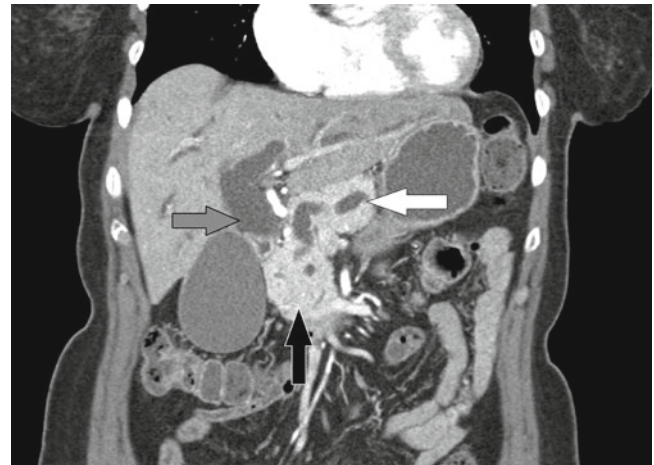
Pancreas protocol CT scan showing a hypo-attenuating mass (black arrow) in the pancreatic head, a dilated pancreatic duct (white arrow), and a dilated bile duct (gray arrow)
